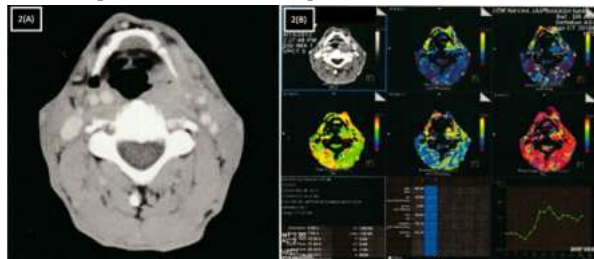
Squamous cell carcinoma larynx (well differentiated). (A) Axial contrast enhanced CT scan showing heterogeneously enhancing mass (arrow) involving left side supraglottic larynx. (B) On perfusion CT map, the lesion stands out clearly. The perfusion values from the tumor (ROI) reveals high tumor blood flow (46.12 ml/100g/min), blood volume (4.21 ml/100g), permeability 21.19ml/100g/min and low mean transit time (3.17 s)
